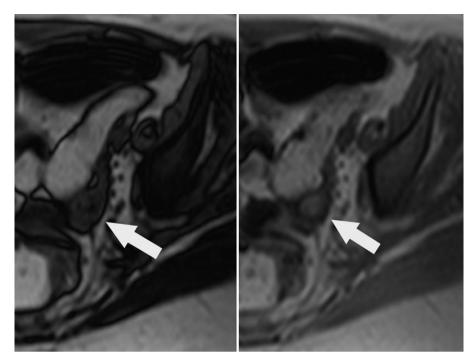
Magnetic resonance imaging of left adnexum. Tumor (arrow) can be seen in both T1-weighted (T1W) out-phase (left) and T1W in-phase images (right).
